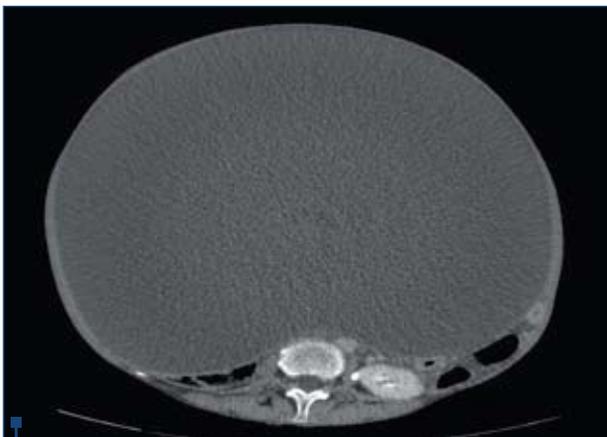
Abdominal CT, cross section. The tumor occupies the entire peritoneal cavity displacing the colon and small intestine towards the back
